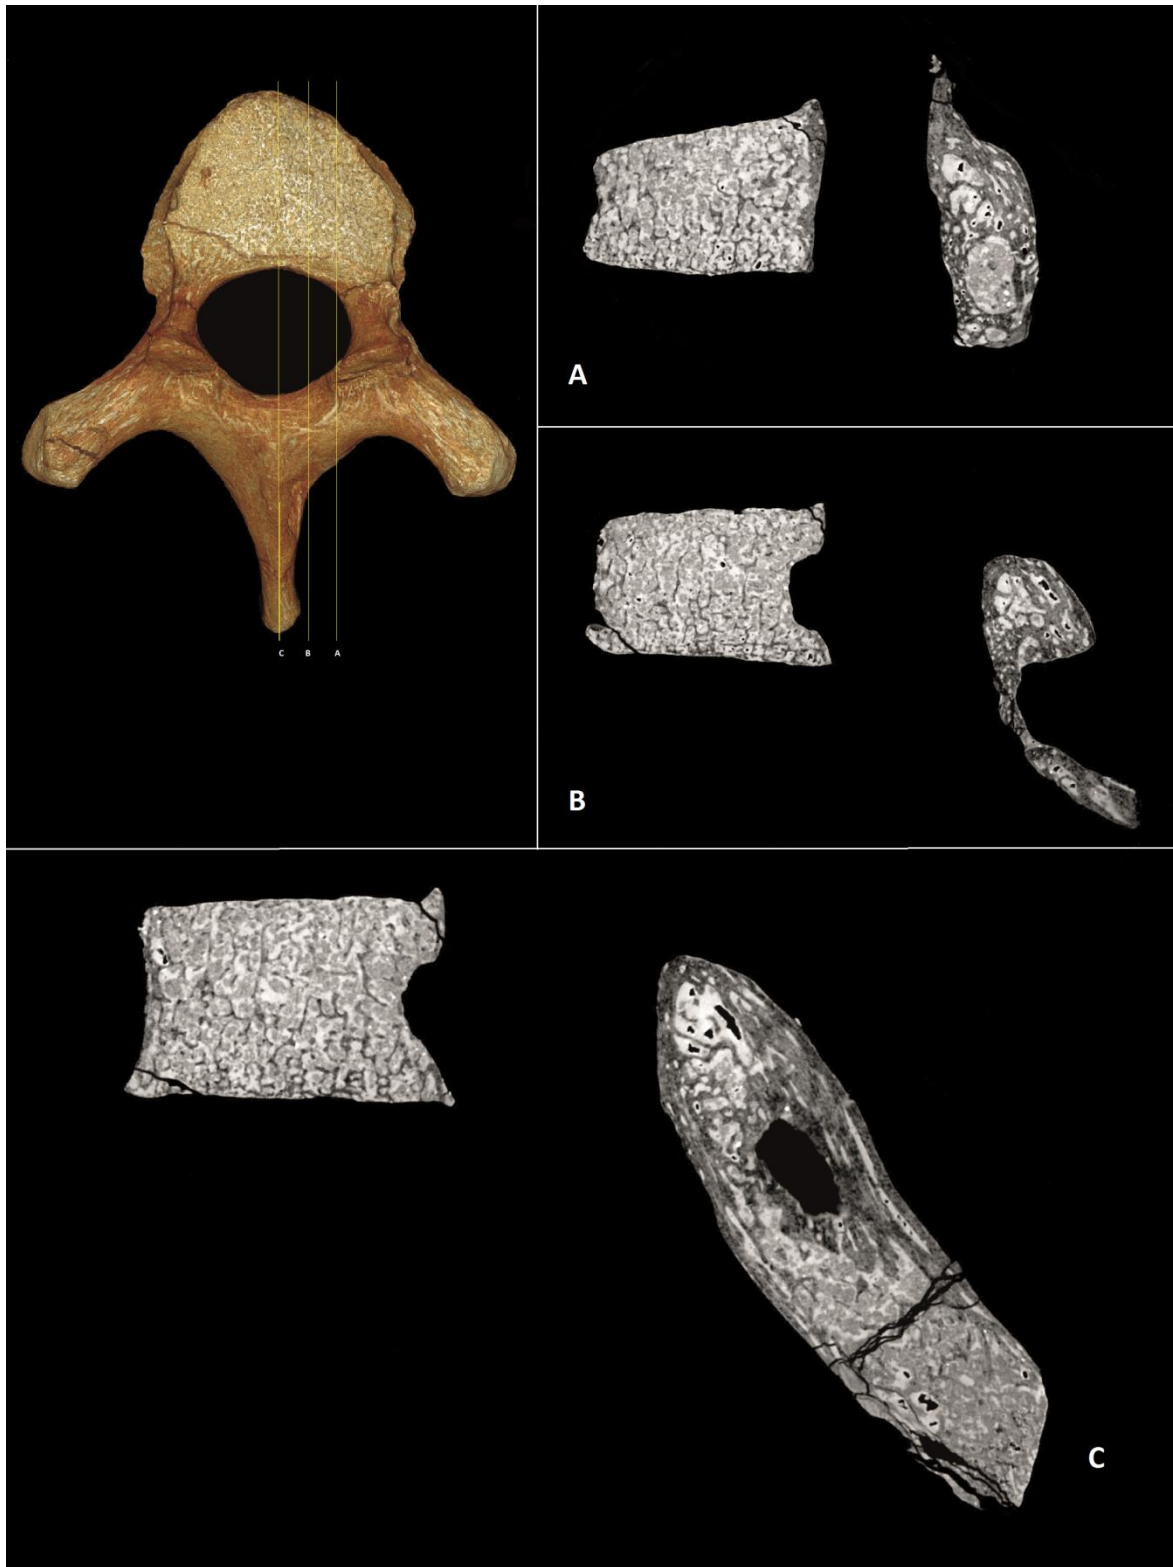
Sagittal slices through vertebra U.W. 88-37 derived from phase-contrast X-ray synchrotron microtomography. Relative position and anatomical orientation of orthoslices A, B and C are shown on the volume-rendered model. The posterior portion is sclerotic, with circumscribed margins of well-integrated cortical bone, abutted and intersected by trabecular striae, with remodelling and reorganisation of the cortex. The anterior portion of the lesion displays a geographic pattern of bone destruction, showing a sharp non-sclerotic margin and evidence of active osteolytic processes, with sharply defined transection of individual trabeculae, and active osteolytic penetration into the anterior portion of the lamina. Images produced by P.S.R.Q.
